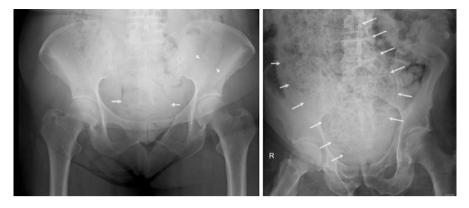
(a) Plain radiograph showing distended faecally loaded rectum but normal sigmoid colon (b) Plain radiograph showing hugely distended faecally loaded rectum in keeping with congenital megarectum
